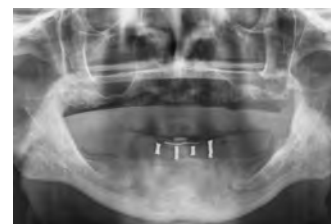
Panoramic radiograph indicates proposed implant positions; excessive vertical bone height is determined
